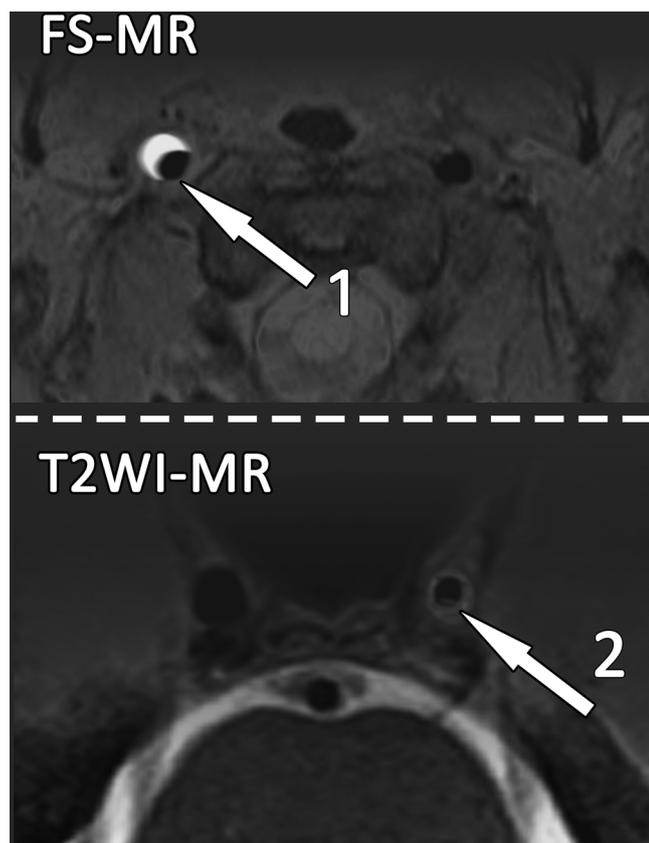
Fat-saturation T1-weighted MR image (FS-MR); IH (intramural hematoma) as a “crescent” sign in the right ICA (arrow 1). T2 weighted image (T2WI-MR), IH and intimal flap (arrow 2) in the left ICA.
